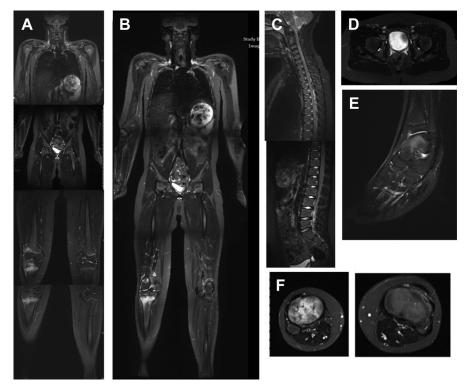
Whole body MRI of a child with CNO includes coronal STIR of total body in 4 to 5 stations (*A*) with stitched image (*B*), sagittal STIR of entire spine (*C*), axial STIR of pelvis (*D*), sagittal STIR of feet (*E*), and axial STIR of the knee (*F*). It demonstrates active inflammation in right proximal tibia and left talus.
